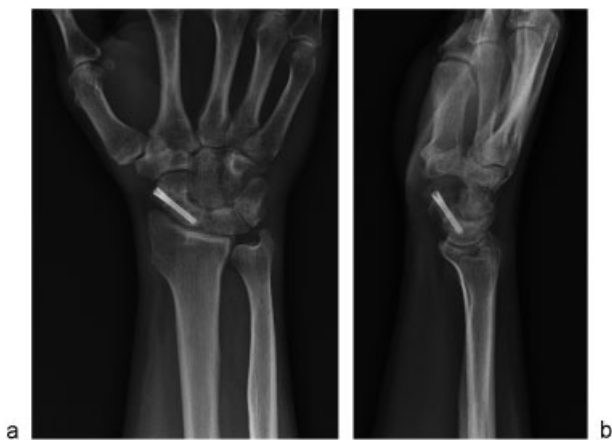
(a) Anteroposterior (b) and lateral views demonstrating the final radiographic outcome at 6 months postoperatively. The scaphoid is completely healed with remodeling of the nonunion site.
